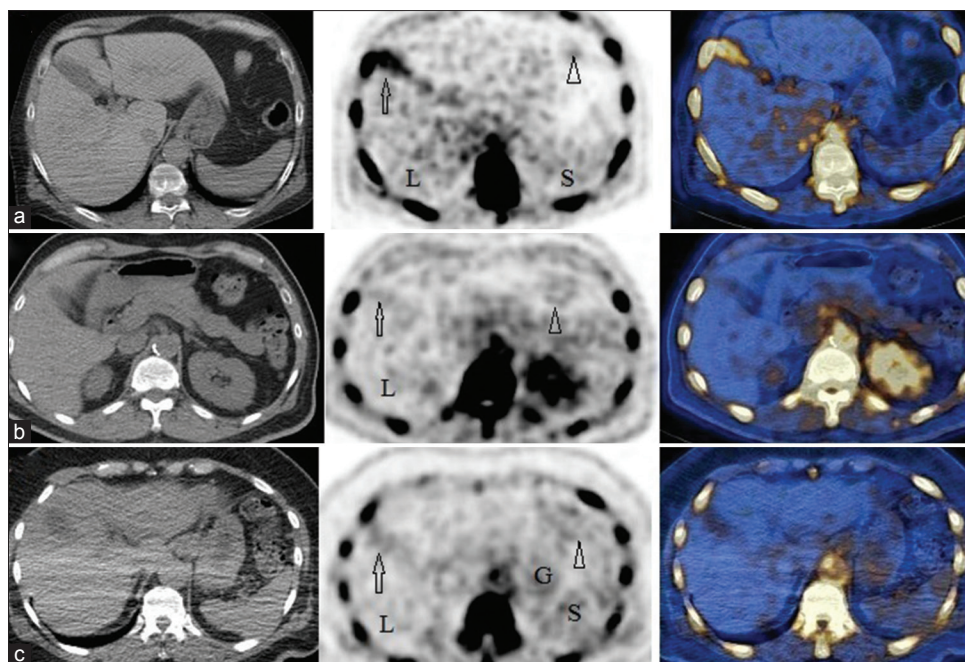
Selected transaxial computed tomography, positron emission tomography, and positron emission tomography/computed tomography fusion images of three patients (a-c) demonstrate mild activity in the gallbladder (arrows) and bowel (arrow heads) and faint activity in the liver (L), spleen (S), and gastric wall (G)
